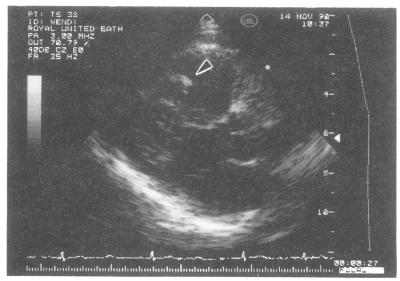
Long axis parasternal view of a control patient showing an echodense area in the apex of the right ventricle (arrowed).
